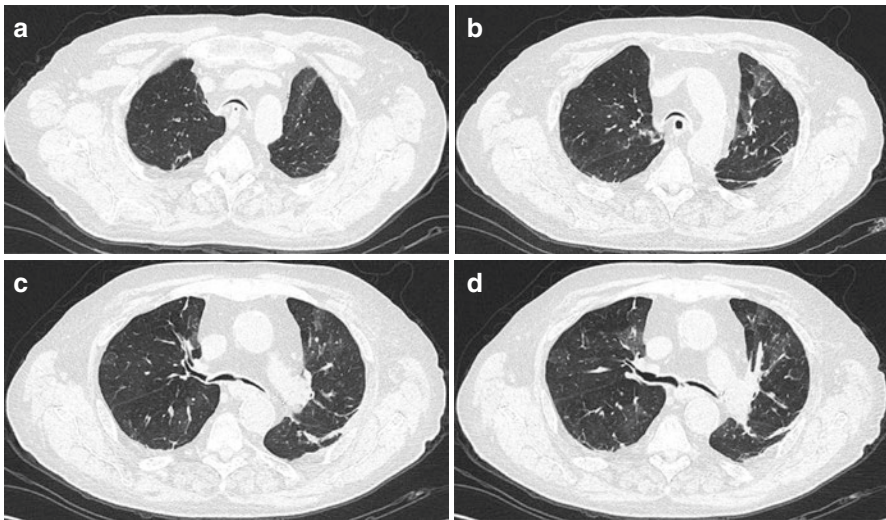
(a–d) Serial axial expiratory CT images (a–d) performed in a 71-year-old male status post bilateral lung transplant demonstrate marked collapse of the trachea and central bronchi (greater than 50% of the luminal cross-sectional area), compatible with tracheobronchomalacia. Slight luminal irregularity is seen at the right mainstem bronchus anastomosis (d), which is a typical finding. There is also evidence of expiratory air trapping, which raises concern for bronchiolitis obliterans
